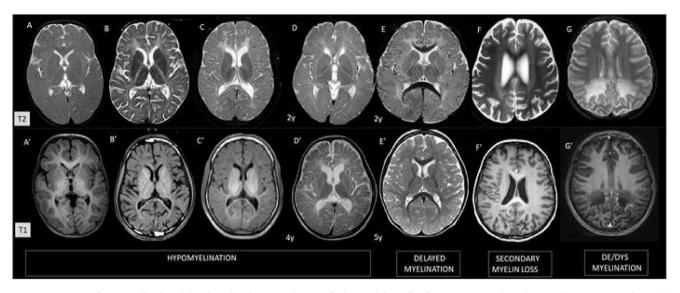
MRI appearance of Hypomyelination, delayed myelination, secondary myelin loss and demyelination. A-A' to C–C' shows hypomyelination on T1 and T2 weighted images with varying degrees of T2 hyperintensity and loss of T1hyperintensity (hyper, iso and hypo to cortex respectively) D-D' is hypomyelination on serial imaging at 2 and 4 years of age showing no progression of myelination. Contrast this to Delayed Myelination(E-E') where the subsequent MRI shows significant increase in myelination. F–F' portrays white matter hyperintensity associated with axonal loss in Neuronal Ceroid Lipofuscinosis. G-G' shows the pronounced T2 hyperintensity and corresponding T1 hypo intensity of demyelinating areas in XALD.
